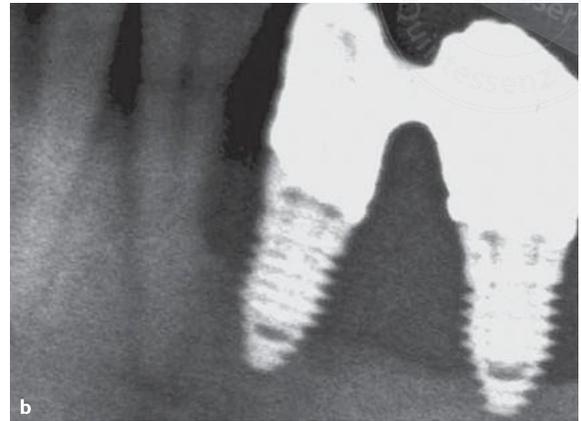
Periapical radiographs of one patient with both 10-mm-long mandibular implants in augmented bone affected by peri-implantitis: (a) at the detection of the disease process (4 years and 1 month after loading); (b) 1 year after treatment when the disease was under control.
